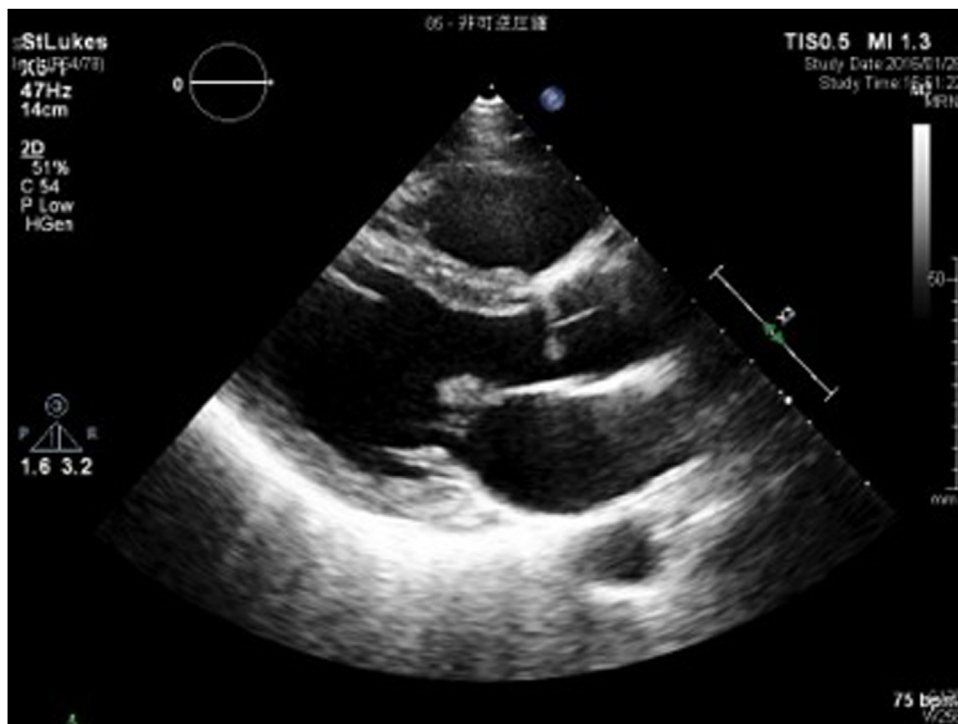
Transthoracic echocardiogram revealed a mobile vegetation measuring 17 mm × 5 mm on the mitral valve.
